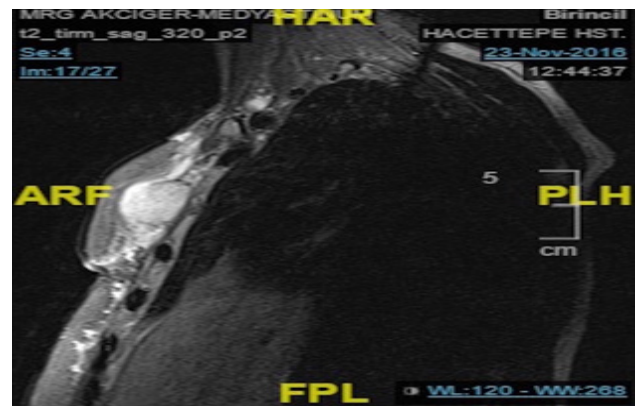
Recurrent tumor beneath the flap. MRI
